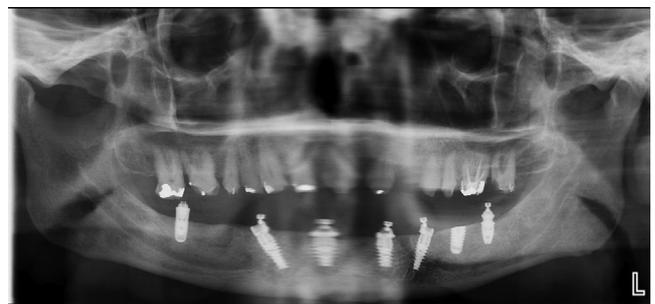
Panoramic radiograph of patient immediately after mandibular implant surgery showing 5 new implants. Previously placed implant at left mandibular first molar site sectioned to bone level and implant at right mandibular first molar site used for immediately loaded prosthesis. Maxillary teeth prepared and protected with acrylic resin interim restorations.
